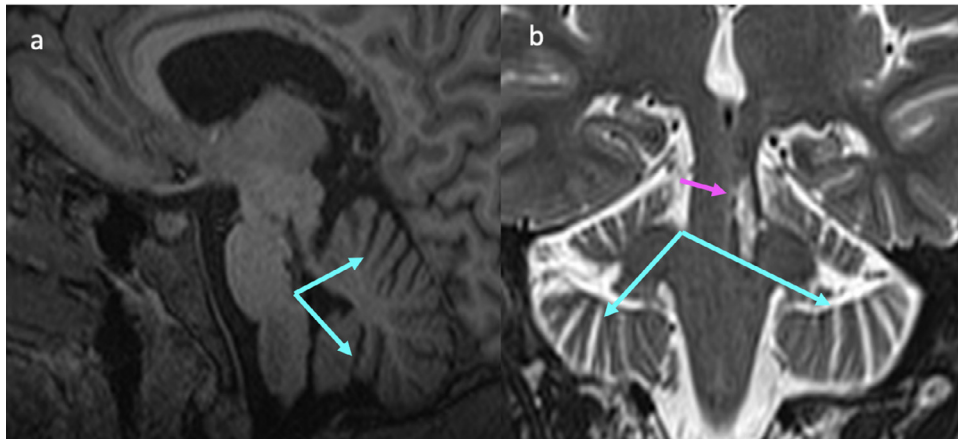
Cerebellar-MRI images on sagittal T1 (A) and coronal T2-weighted (B) sections reveal a discrete enlargement of the cerebellar cortical sulci (Blue arrows), corresponding to a cerebellar atrophy. Note the coronal section of the pontomesencephalic hemorrhagic cavernoma (Pink arrow).
